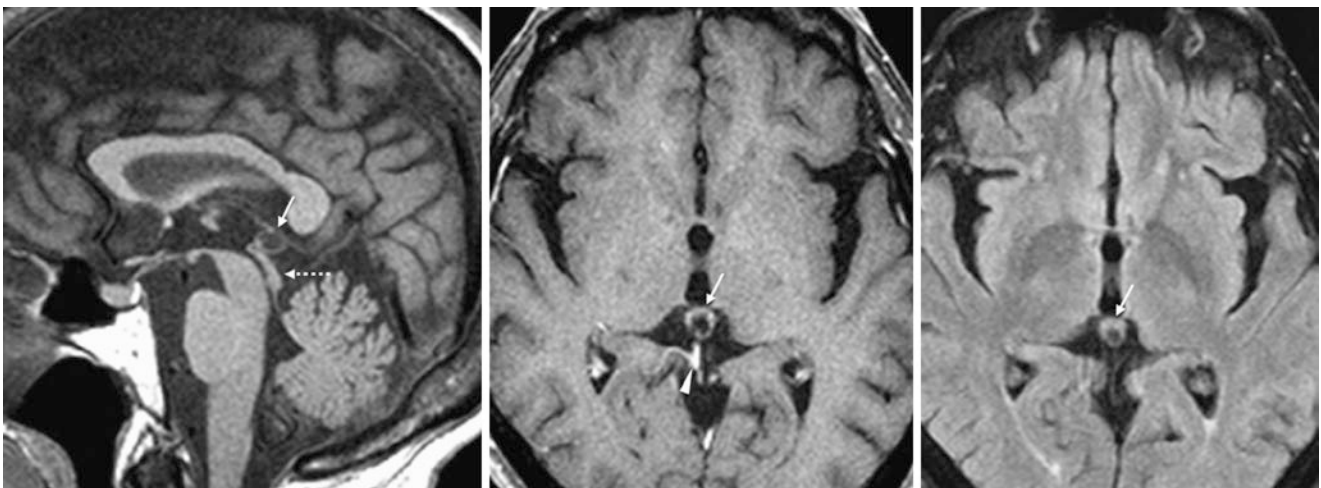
A 64-year-old patient with a small, 9-mm pineal cyst (*thin arrows*) adjacent to but not compressing the tectum (*dotted arrows*) on a 5-mm thickness sagittal T1WI (*left*), axial postcontrast T1WI (*middle*), and axial FLAIR (*right*) images. The cyst has a slightly thickened
